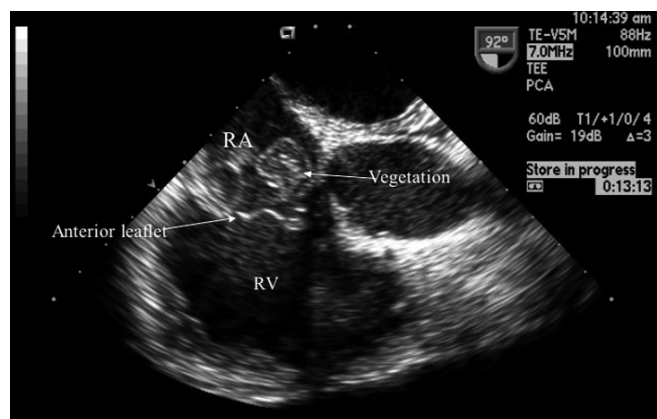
Preoperative transesophageal echocardiogram showing a large mobile vegetation. RV indicates right ventricle; RA, right atrium.
